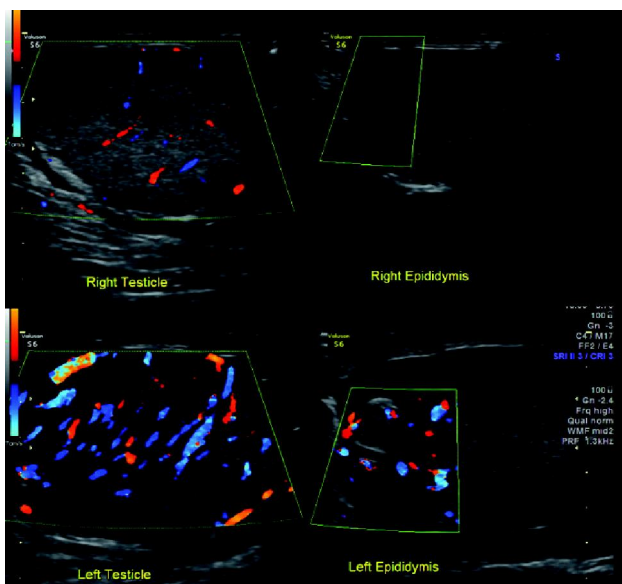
Ultrasound scrotum of a 31-year-old male presenting with scrotal pain for duration of 8 hours. It is showing swollen and hypoechoic left testis and epididymis with increased vascular flow on color doppler scan. He was diagnosed as having acute epididymoorchitis.
